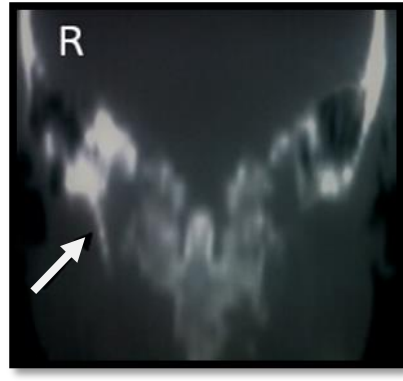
3D CT scan, showing elongated styloid process on the right side.
